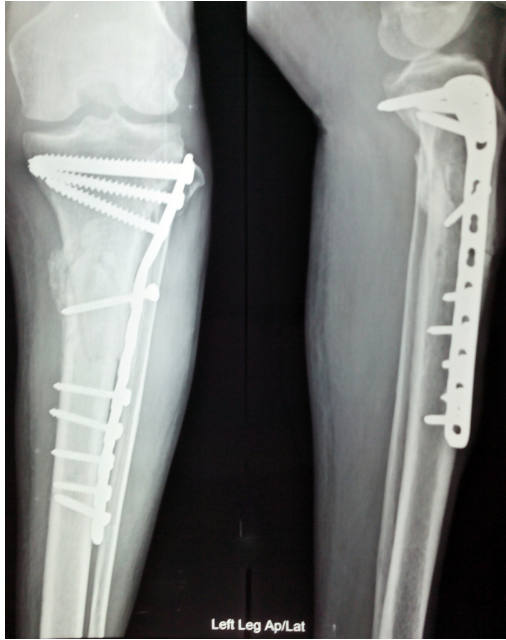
Anterior and lateral view x-rays of fractured left leg with internal fixation [2].
